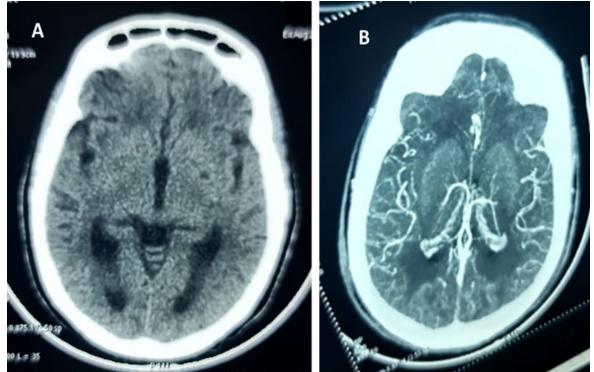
Cerebral CT (A) with agiographic acquisition (B) showinglacunarleftlenticularhypodensity suggestive of an ischemiclesion of the territory of the deep middle cerebralartery.
